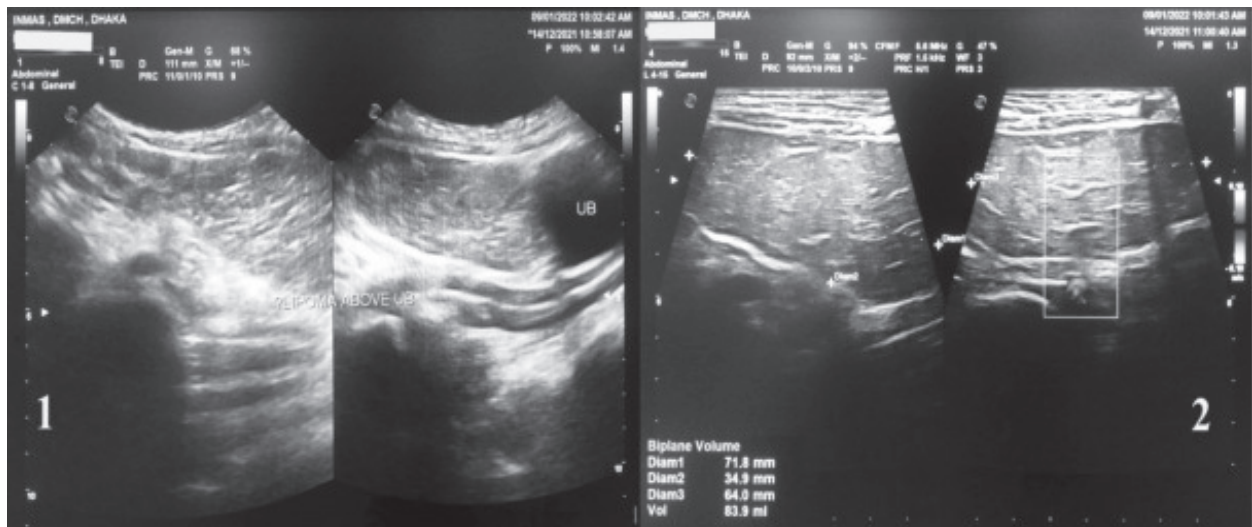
Sonographic pictures including high resolution scans showing a well outlined mixed echogenic mass (measuring $\sim 7.2 \times 3.5 \times 6.4$ cm) outlined by a thin echogenic capsule, located just above urinary bladder and beneath parietal peritoneum. On Doppler no flow is noted inside the mass.
